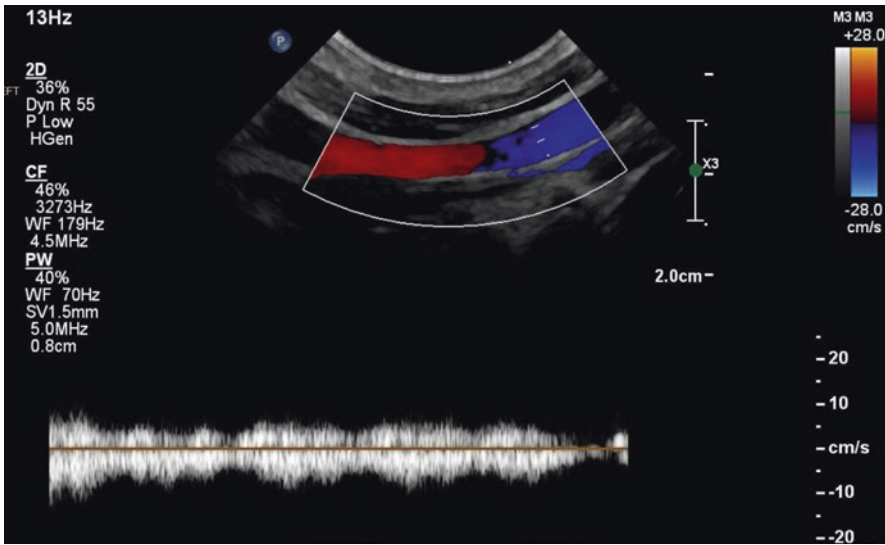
Pulsed wave doppler of the jugular vein displays the classic continuous venous flow
